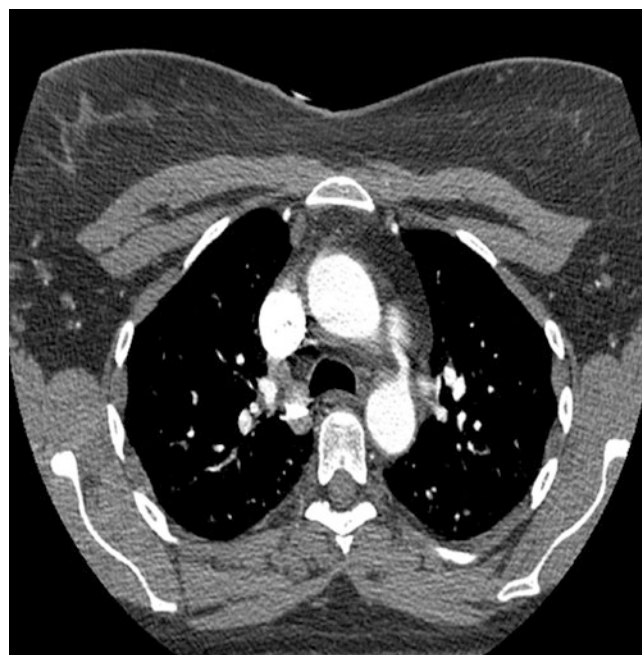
CT Pulmonary Angiogram in an adult with incidental diagnosis of a small patent ductus arteriosus (arrow). The ductus is a communication between the descending aorta and the base of the left pulmonary artery
